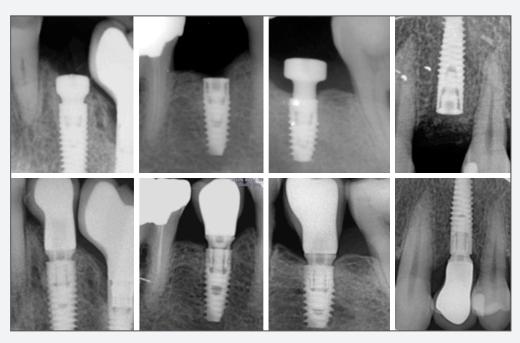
Periapical radiographs with an intraoral dental film using a plastic index according to the parallel technique for marginal bone loss (MBL) analysis between baseline and 1 year follow-up.
